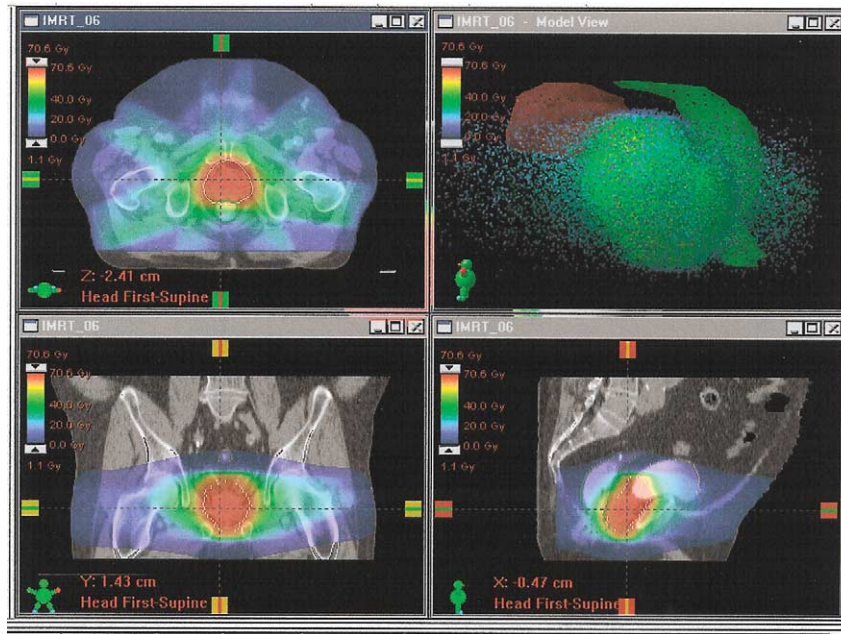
Example of dose distribution planned for the treatment of a prostate cancer with external beam radiotherapy. 3D dose distributions are calculated with 3D anatomical data from CT images of a patient. To make a first evaluation of the treatment plan, 2D isodose curves (colour coding) are analysed on characteristic plans (sagittal/bottom right, frontal/bottom left, transverse/top left). A 3D display of the target volume is presented in top right image.
